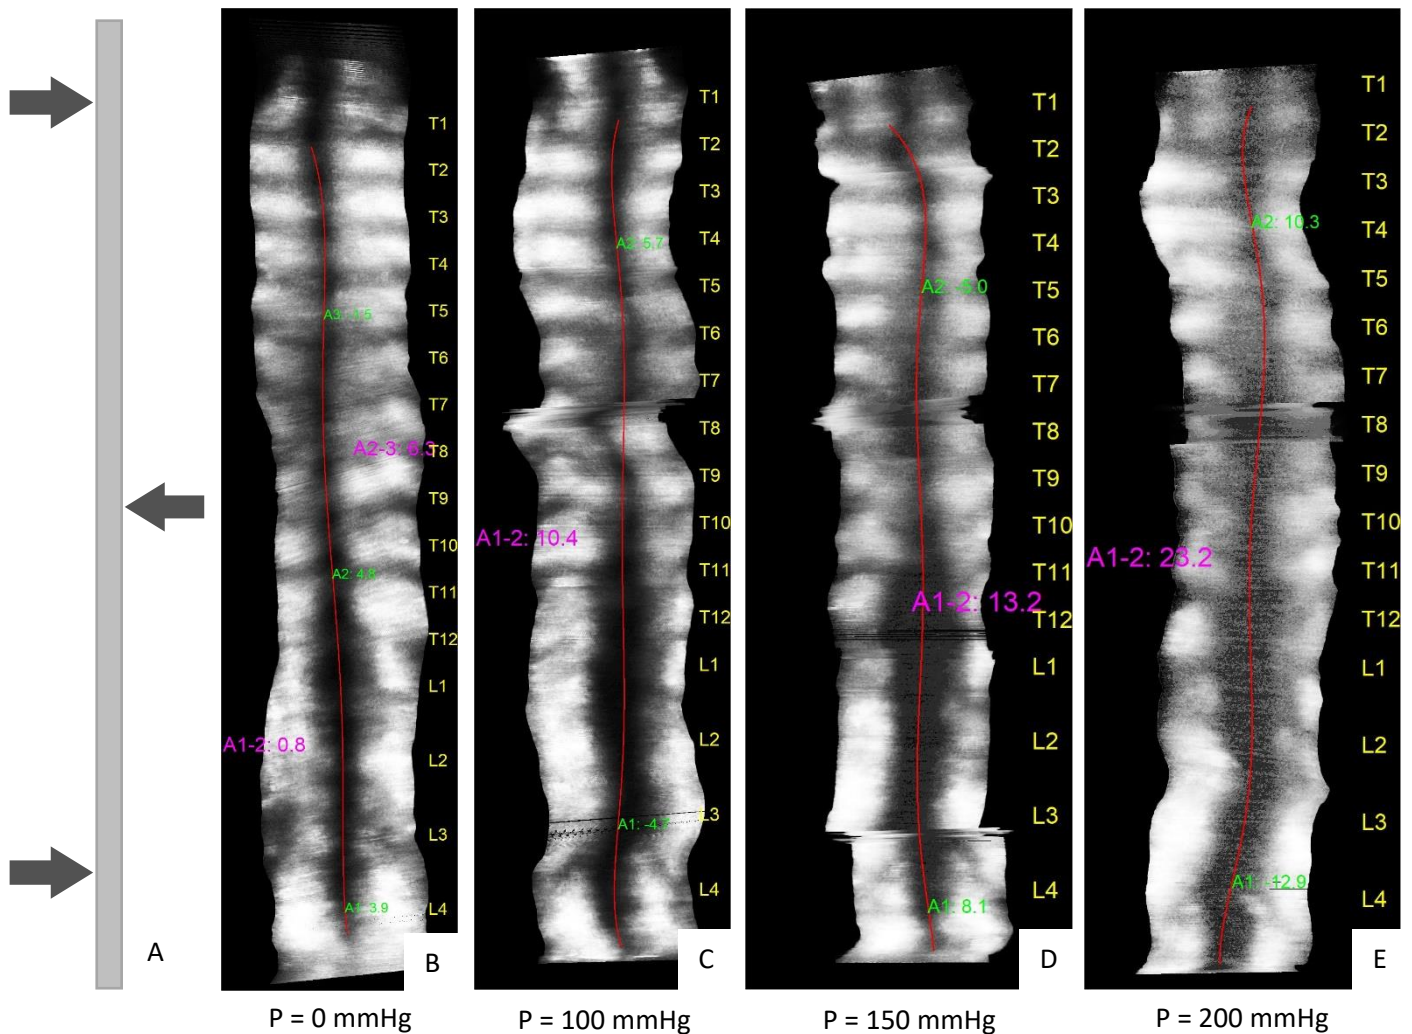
A: posterior visualization of the pressure area directions, creating a three-point pressure system. B-E: Ultrasound images taken right after increasing the pressure value in every meter equally. The purple values indicate the automatically measured spinal angle by the Scolioscan software. In yellow the individual vertebrae are indicated. Image B shows the result brace wear without inflation of the cuffs. Image C shows the results when all cuffs are inflated to 100 mmHg, which is increased with 50 mmHg for the following measurements.
